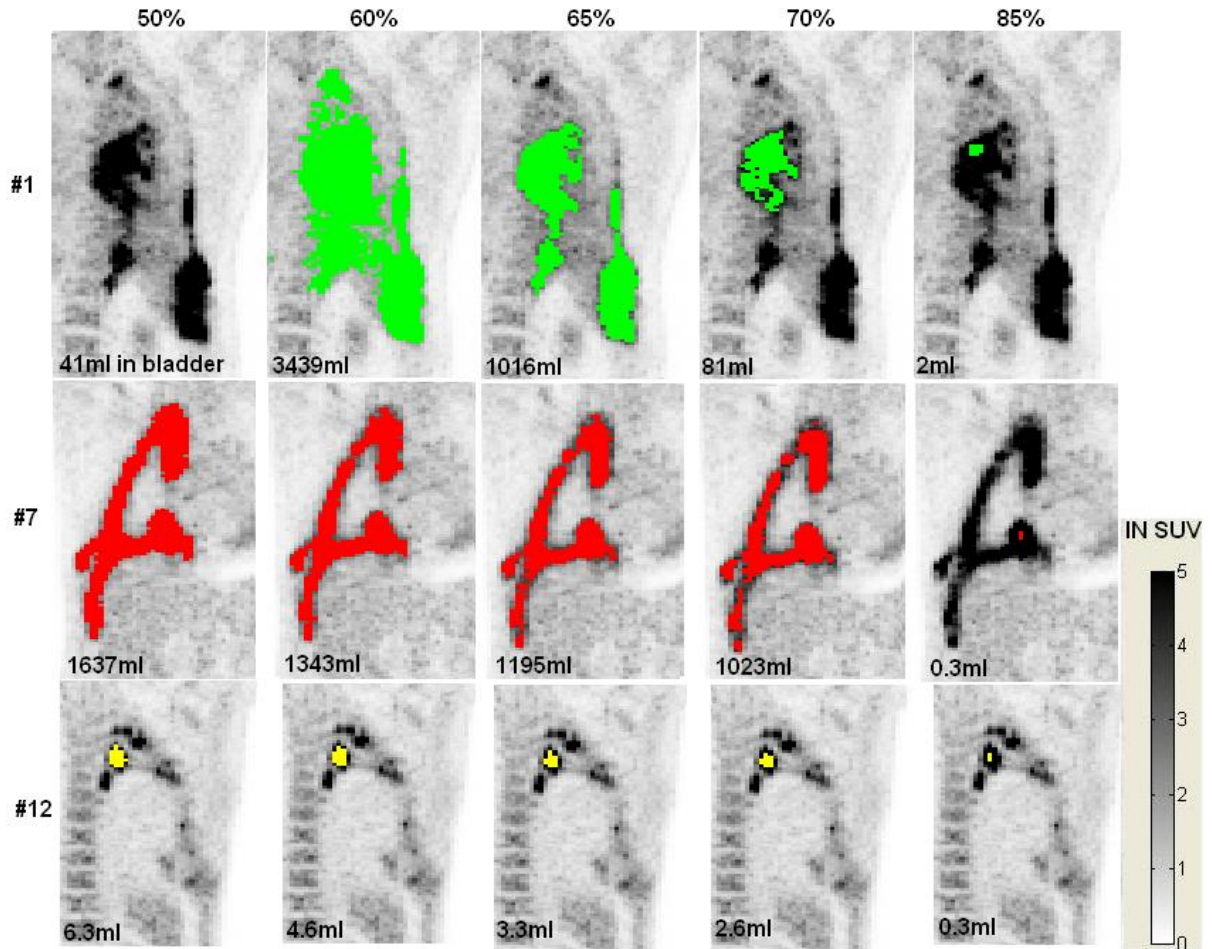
Segmentation using Adaptive SUV_{mean}
